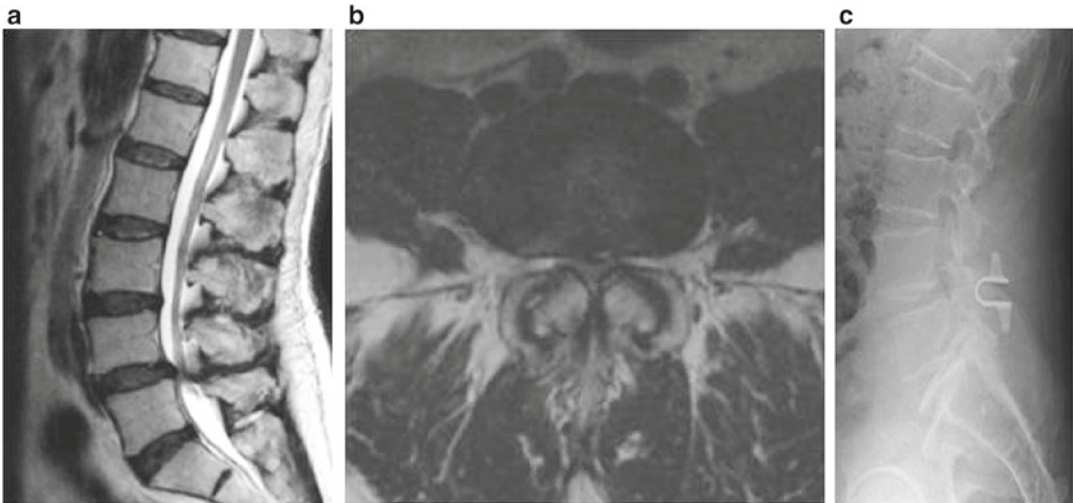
(a). Sagittal and (b). axial T2-weighted magnetic resonance images revealing severe stenosis at L4-5 and Grade 1 spondylolisthesis. (c). The lateral plain radiographic image reveals proper placement of a dynamic
